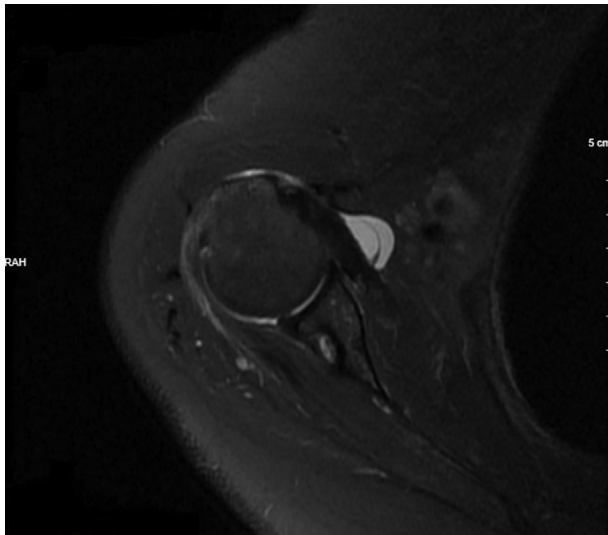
Preoperative magnetic resonance image of a patient with subcoracoid cyst formation.
